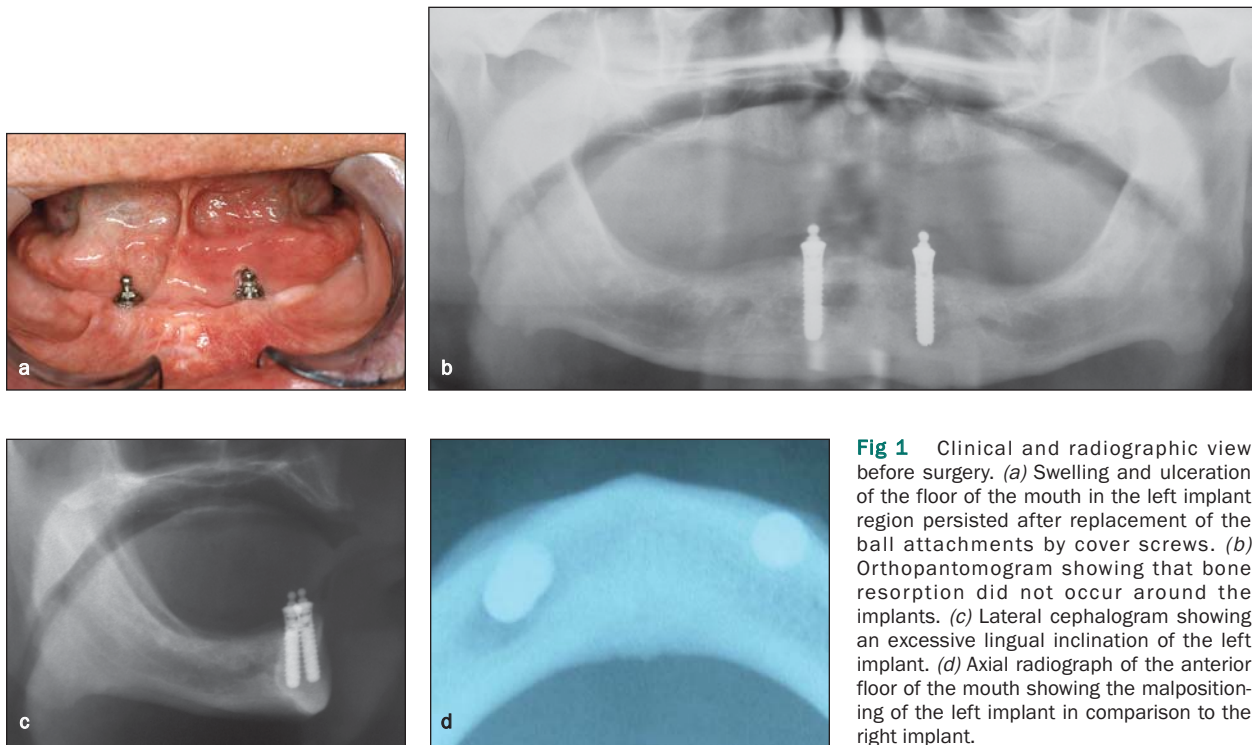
Clinical and radiographic view before surgery. (a) Swelling and ulceration of the floor of the mouth in the left implant region persisted after replacement of the ball attachments by cover screws. (b) Orthopantomogram showing that bone resorption did not occur around the implants. (c) Lateral cephalogram showing an excessive lingual inclination of the left implant. (d) Axial radiograph of the anterior floor of the mouth showing the malpositioning of the left implant in comparison to the right implant.
